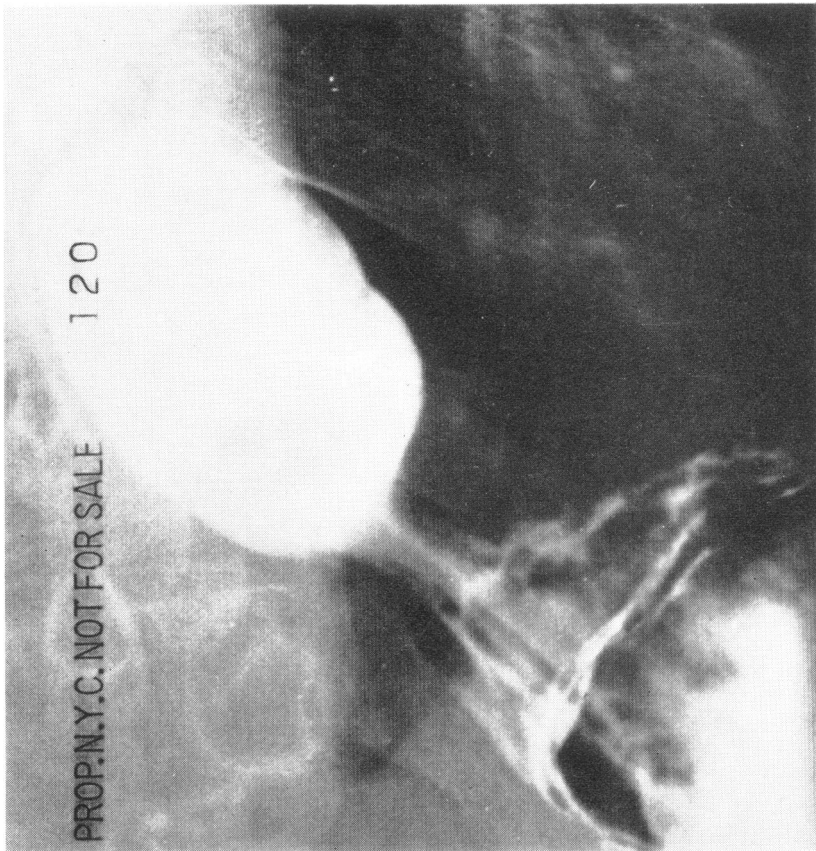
Simultaneous demonstration of phrenic ampulla and cardiac antrum, the former filled with barium, the latter containing air. The barium-coated walls of the cardiac antrum suggest a border line between stomach and esophagus. This radiograph seems to refute the unitarian view held by a minority of anatomists and radiologists, according to which only a single "cardioesophageal vestibule" exists.
